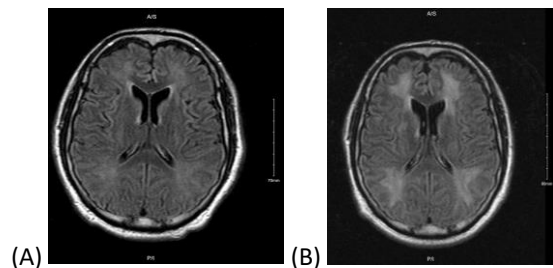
FLAIR: (A) Initial MRI FLAIR with nonspecific white matter changes; (B) Repeat MRI with extensive diffuse bihemispheric confluent and symmetric white matter T2 hyperintensities.
